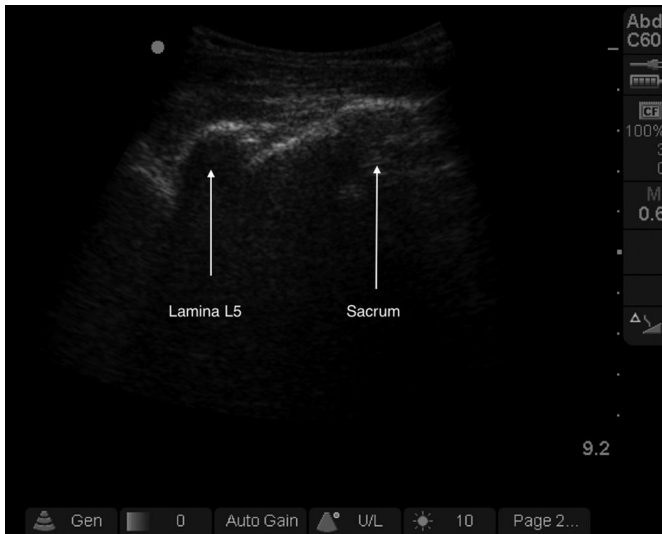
Ultrasound view of Sacrum in Paramedian sagittal oblique view (PSO plane).
